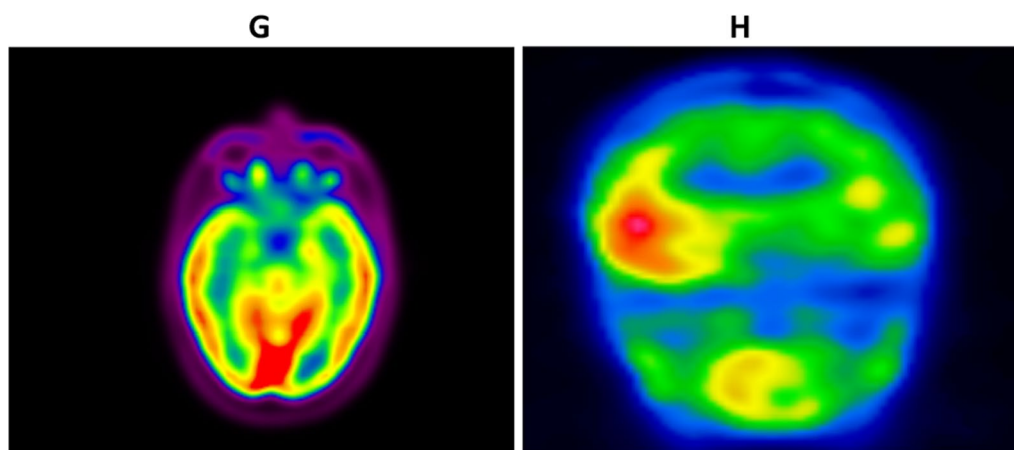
PET/CT brain scan shows mild asymmetrical hypometabolism of the right temporal lobe is more evident in the medial region (G), and ictal SPECT shows ictal hyperperfusion on the right temporal lobe (H)
